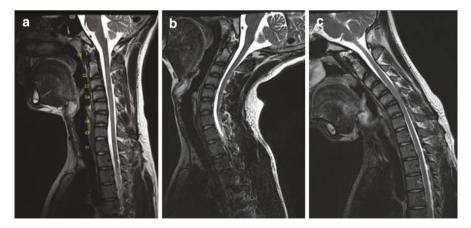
MRI of the cervical spine, T2-weighted sagittal sequences (Fig 25.1) with flexionextension views confirmed Hirayama disease. (a) revealed a mild loss of normal cervical spine lordosis. Extension view (b) revealed CSF anterior to the spinal cord. Upon neck flexion (c), MRI demonstrates loss of CSF spaces and compression of the cord at C5–6
